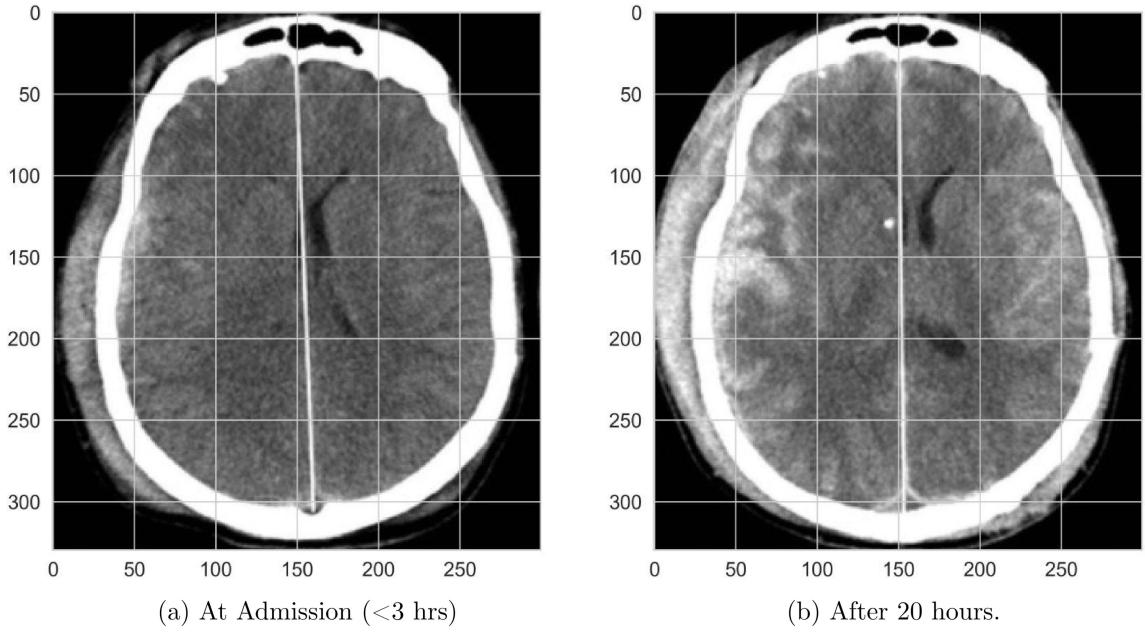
CT scan of a patient with Midline Shift due to traumatic brain injury taken at admission and after 20 hours.
